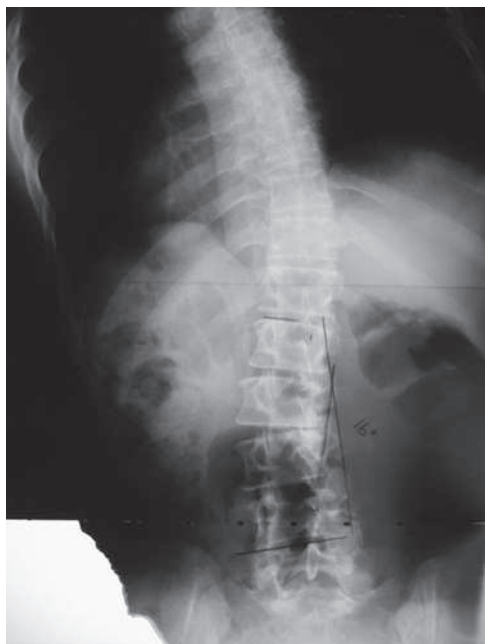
Lumbar spine radiograph of active individual that demonstrates significant scoliosis.
